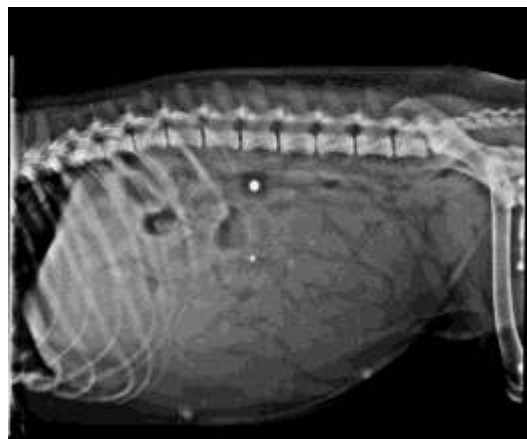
Plain radiograph showing dilated fluid filled intestinal loops (White dot is an artifact)
